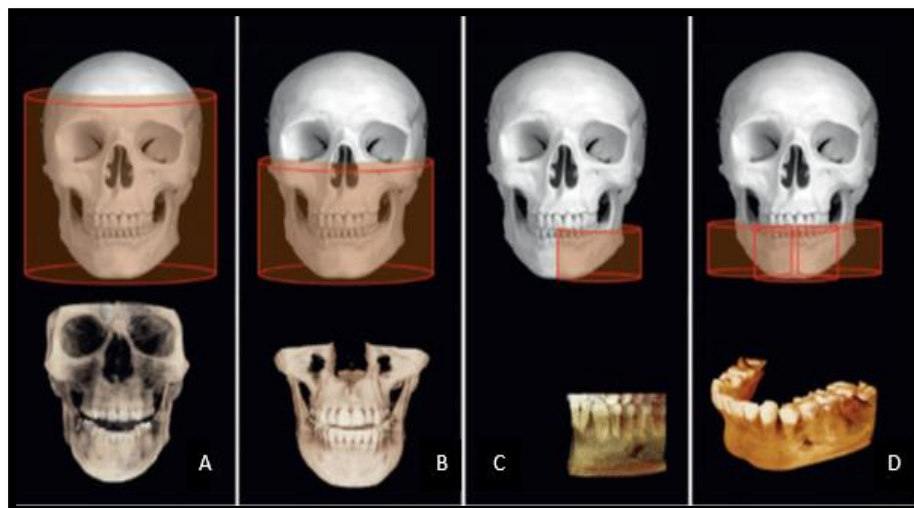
Classification of the CBCT units on the basis of FOV. Large FOV (A), medium FOV (B), focused (small) FOV (C), stitching of multiple focused scans (D)
